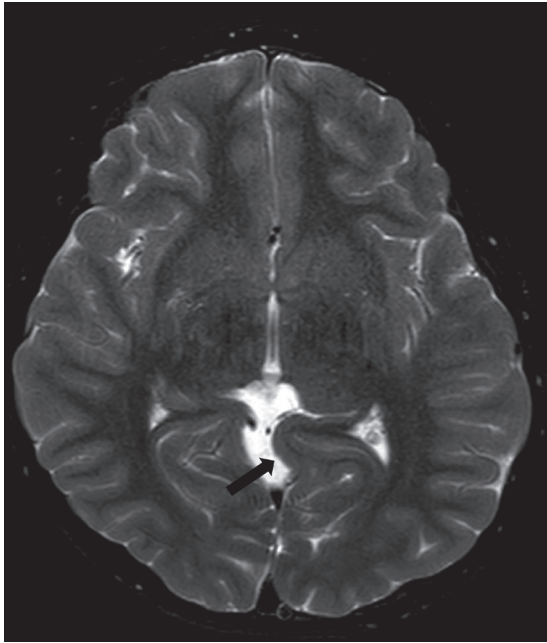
Axial T2-weighted brain MR image shows unilateral cuneate gyrus herniation on the left (black arrow)
